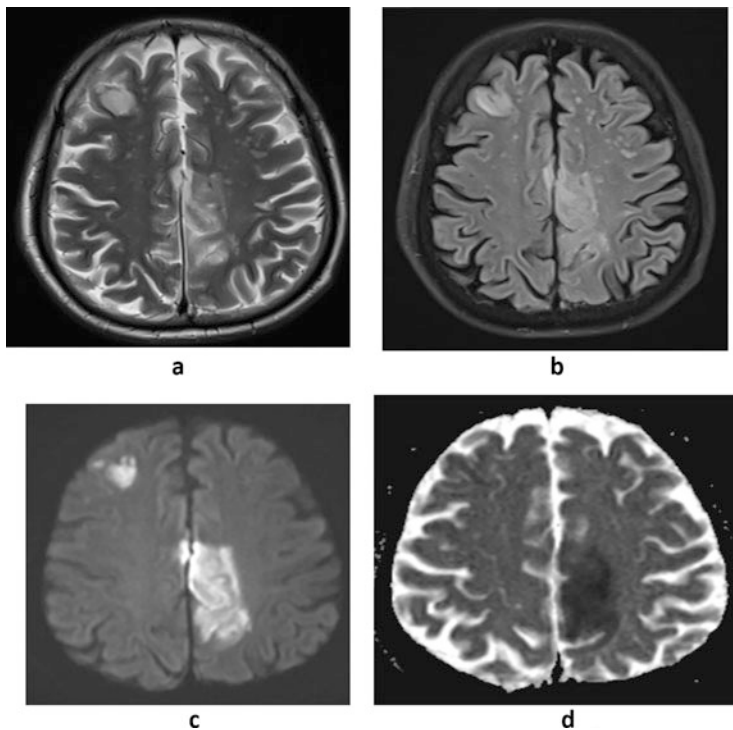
Axial MRI of brain showing area of altered signal intensity involving right frontal lobe and left parietal lobe. It appears hyperintense on T₂WI (a) and FLAIR (b) images. The area shows restriction on DWI (c) and ADC (d) images consistent with acute infarct
